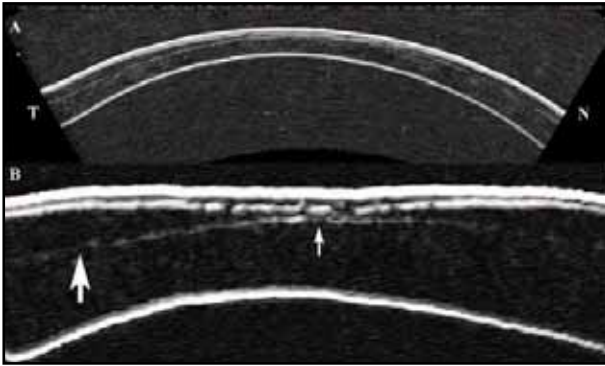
Horizontal VHF digital ultrasound B-scan through the visual axis of a cornea 3 months after LASIK for -10.00 which produced a gross overcorrection to +4.00 D. The geometrically correct image is shown above (A) with the raw scan data axially zoomed below (B). The flap is seen to be much thinner centrally (small arrow) than peripherally (large arrow). This unplanned, extreme, mid-peripheral, deep keratectomy explains the gross overcorrection. Central flattening occurred as a function of three mechanisms acting together: laser ablation, radial keratotomy-like peripheral bulging with central flattening, and Roberts'-like peripheral corneal thickening due to lamellar relaxation producing increased central flattening. Clearly, relifting of this flap and further midperipheral ablation (as would have been carried out before this diagnostic test) would risk exacerbating the hyperopic shift by further unpredicted biomechanical changes in the cornea.
